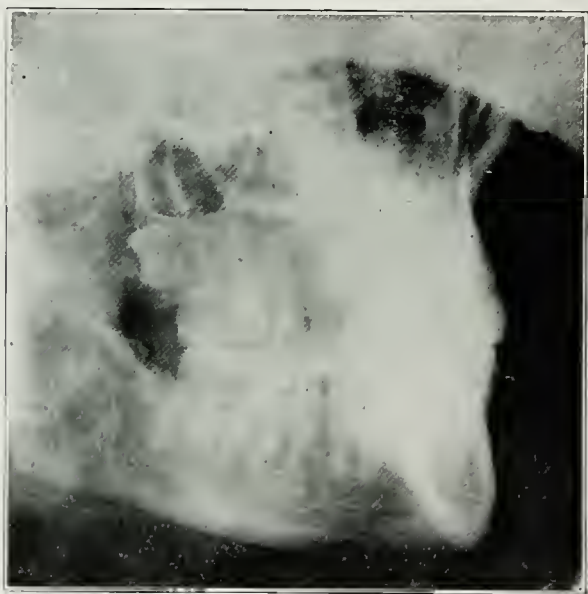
Roentgenogram of left side of face showing anatomic landmark and an impacted upper third molar. (*From R. H. Ivy.*)
